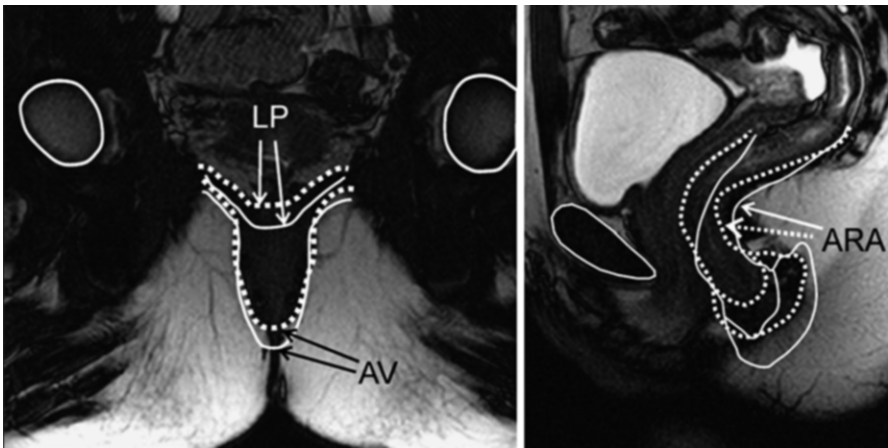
Magnetic Resonance images (MRI) in the mid-sagittal and coronal planes: these images were obtained at rest (solid) and squeeze (dotted) and the images were overlapped to show the movements of various structures during squeeze. LP levator plate, AV anal verge, ARA ano-rectal angle
